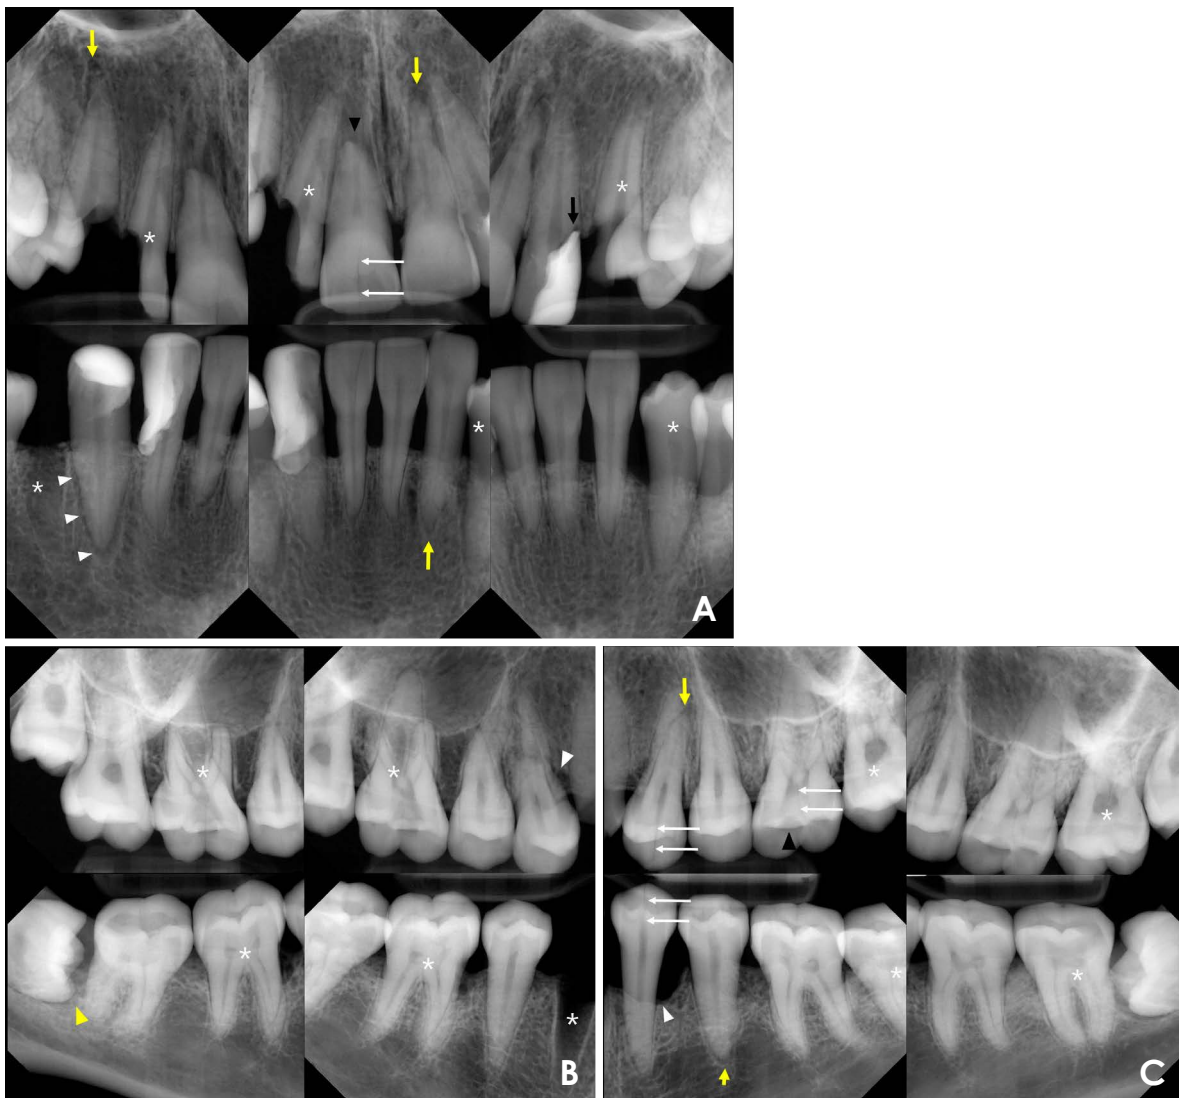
The lesions present in the dry skull were confirmed using periapical radiographs. *: Following tooth extraction or using an existing extraction socket, a new tooth with reproduced lesions was implanted within the socket. A. Anterior area. Black arrow: secondary caries; white arrow: vertical crack; yellow arrow: periapical periodontal ligament (PDL) space widening or periapical rarefaction; black arrowhead: external root resorption; white arrowhead: periodontal bone loss. B. Right area. White arrowhead: periodontal bone loss; yellow arrowhead: pericoronitis. C. Left area. White arrow: vertical crack; yellow arrow: periapical PDL space widening or periapical rarefaction; white arrowhead: periodontal bone loss; black arrowhead: loss of filling material.
